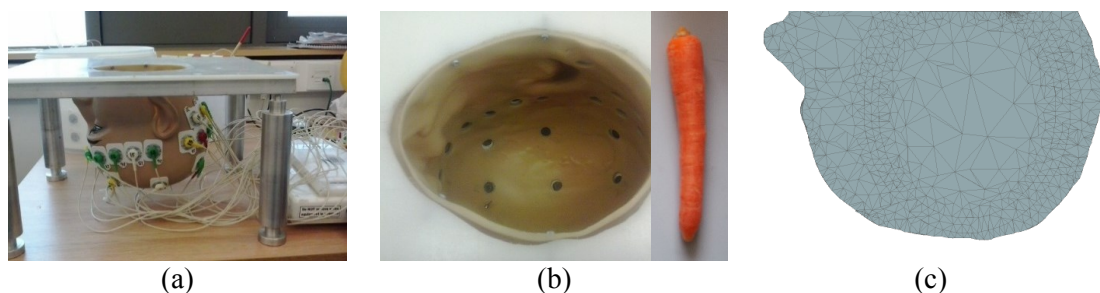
3 Experiment configuration of Case 3: (a) the head-like tank filled with saline, (b) the arbitrary geometry of the tank and the carrot used as the inclusion, (c) the inverse model constructed from the MR image of a human
